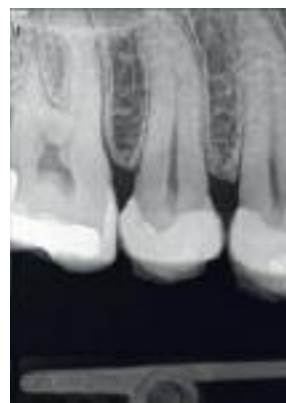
Radiograph after Biodentine™ placement.
